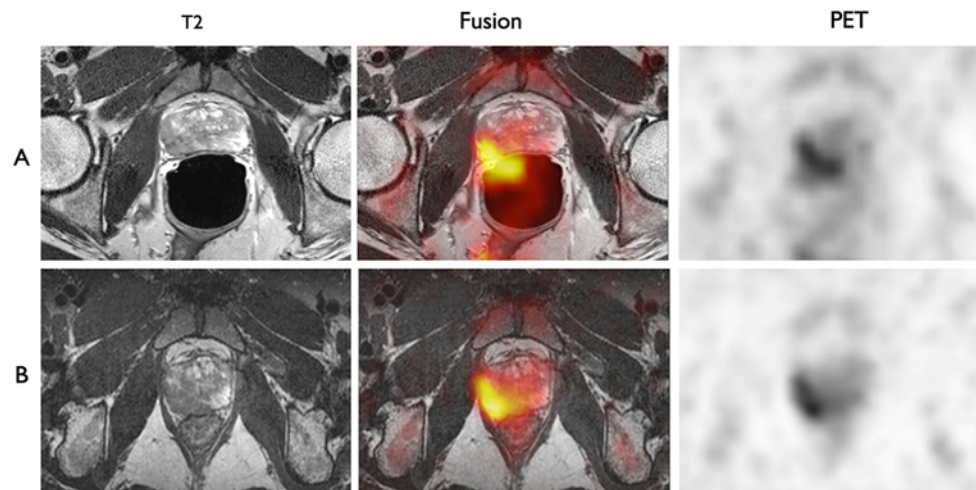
Effect of the endorectal coil on the PET/MRI registration. On the left, axial T2 images of a prostate with a large right peripheral zone cancer, as demonstrated by a hypointense area. The tumor is visible on both the T2-weighted images acquired with an endorectal coil (row a left) and on the images obtained with an external phased-array coil (row b left). On the PET images, the tumor is characterized
